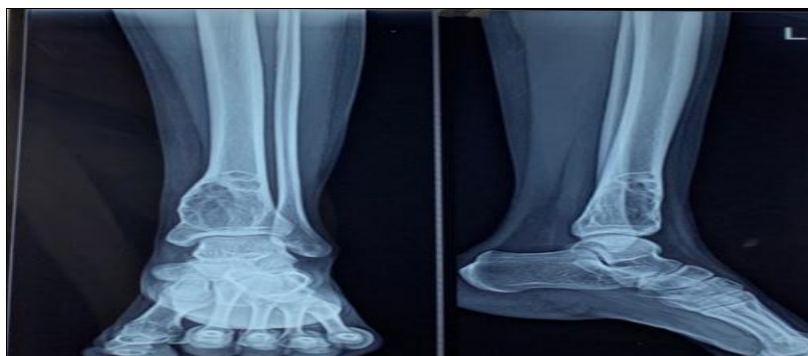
Showing Pre-Operative X-Ray Left Ankle AP and Lateral View Showing Well-Defined Expansile Lytic Lesion At Distal End Of Left Tibia Suggestive Of Giant Cell Tumor of Distal End Tibia
